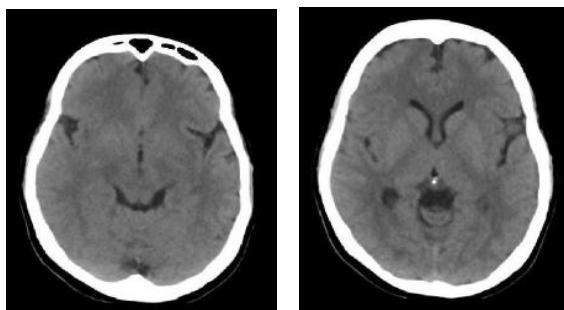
Axial images of cranial CT scan showed no abnormality
